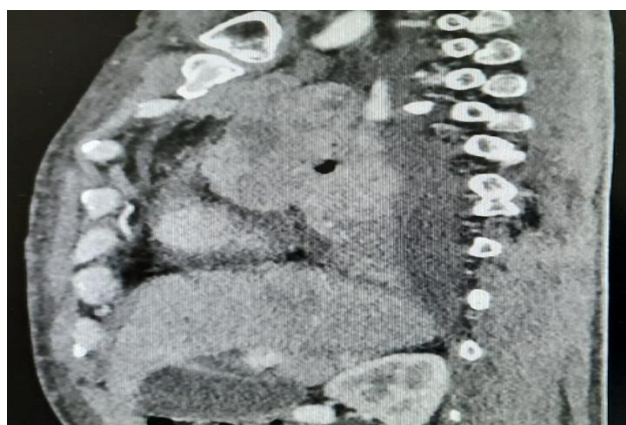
Contrast enhanced computed tomography showing mass with center right lung mass.
